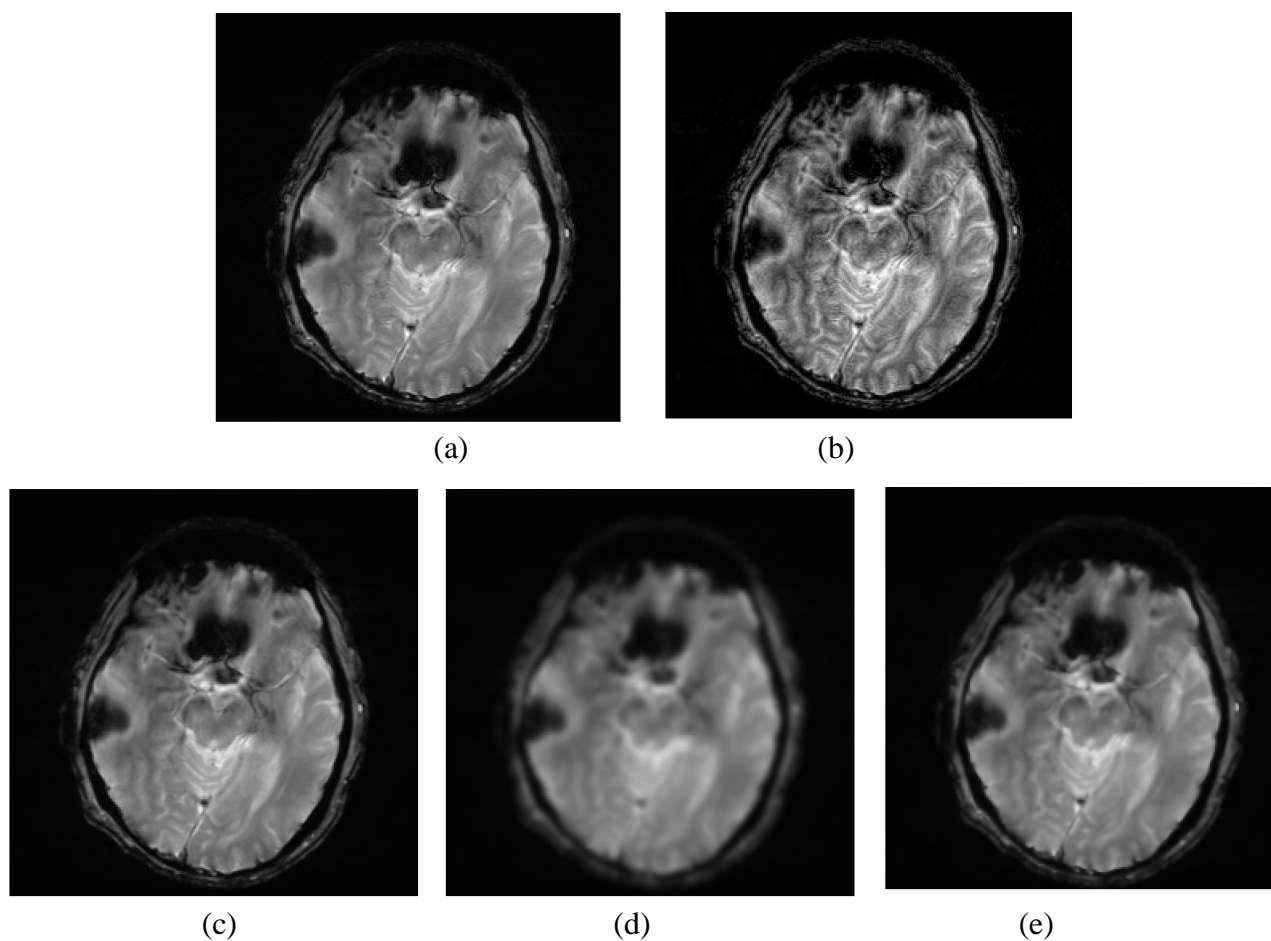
Pre-processed MRI images – Double Window Median Filter
